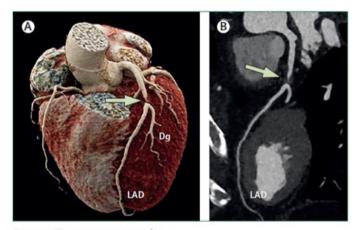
CT coronary angiography
